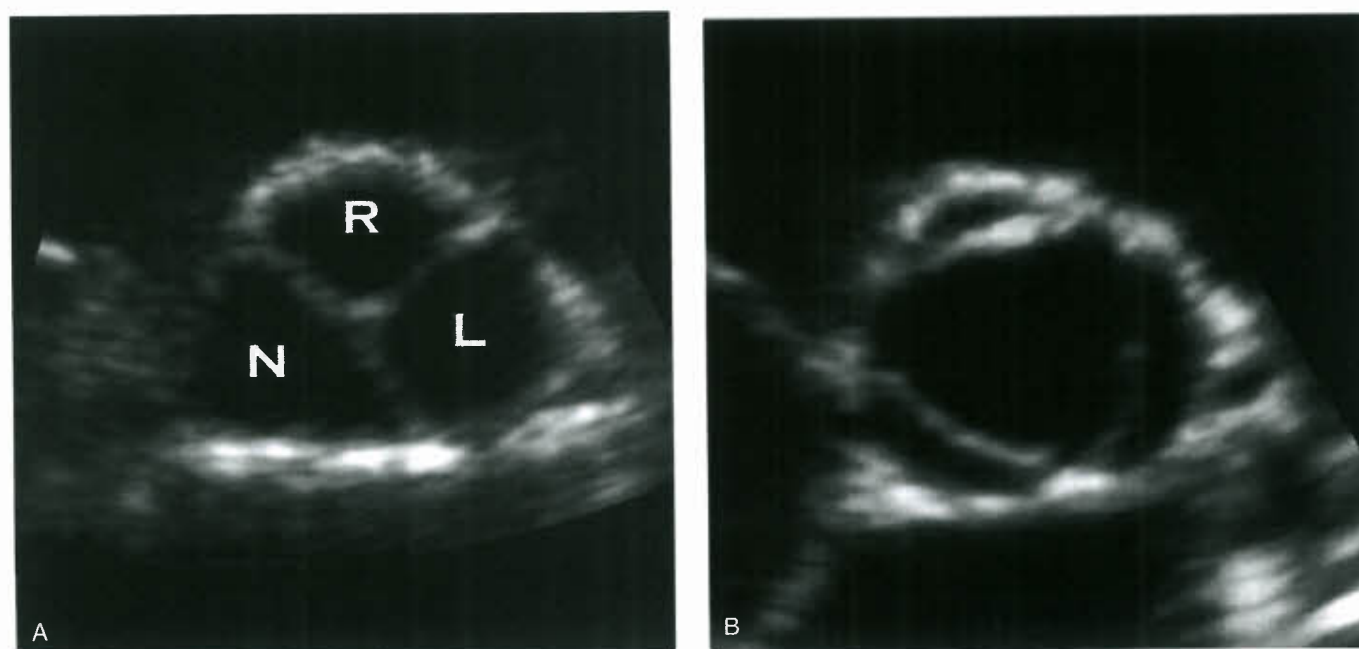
Echocardiographic parasternal short-axis views of a normal tricuspid aortic valve. A: Diastole. B: Systole. R, right coronary cusp; L, left coronary cusp; N, noncoronary cusp.
